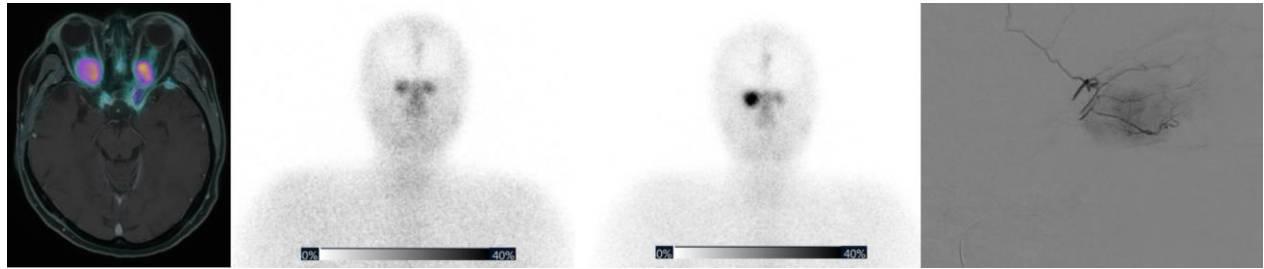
A. Pre-treatment ^{68}Ga -DOTATOC PET fused with MRI showing multiple meningiomas, especially bilateral optic meningiomas, causing blindness and proptosis induced pain complaints. Post-treatment ^{177}Lu -HA-DOTATATE planar image after intravenous (B) and intra-arterial treatment (C) showing a clear increased accumulation in the right optical meningioma (arrow) by intra-arterial treatment, but to the contralateral optical meningioma (treated by second pass). D. corresponding digital subtraction angiography of the intra-arterial administration. Patient had stable disease on imaging and proptosis induced pain complaints subsided.
